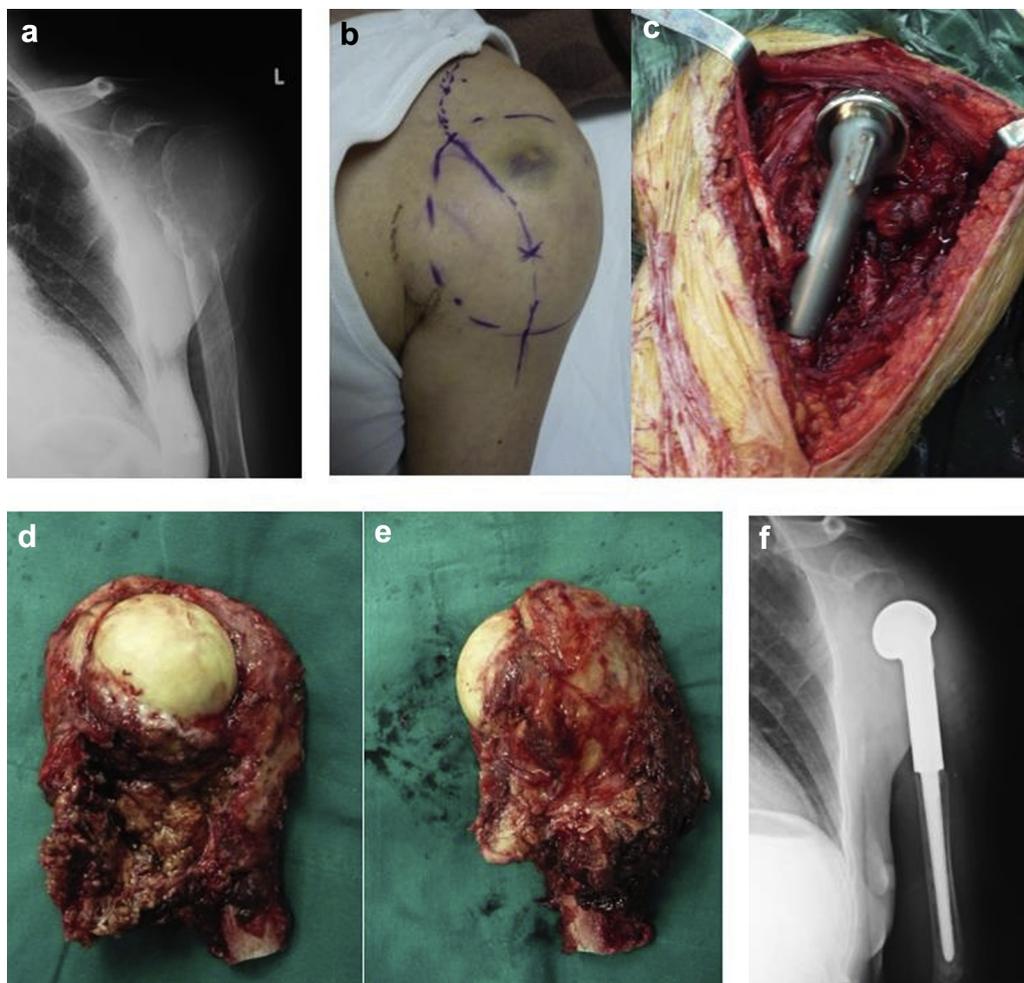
Left-sided Campanacci grade III proximal humerus giant cell tumor in a 55-year-old woman (case 24 in [Table I](#)). (a) A preoperative radiograph shows fracture displacement. (b, c) Surgical approach and intraoperative endoprosthesis. (d, e) Resected tumor segment. (f) A postoperative radiograph shows subluxation of the glenohumeral joint. *L*, left.
